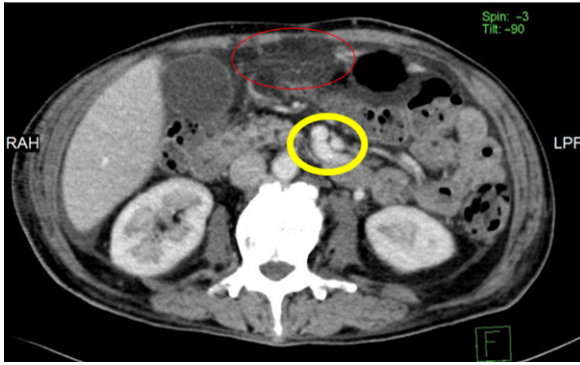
Axial CT image from upper abdomen showing stranding in the omentum (red circle) and in central mesentery (yellow circle).
